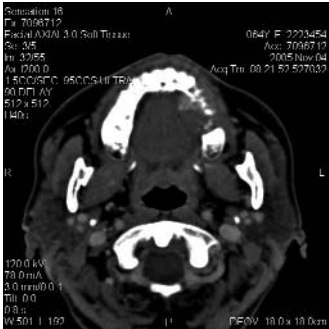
Soft- and hard-tissue CT, respectively, of same lesion with an axial view.
